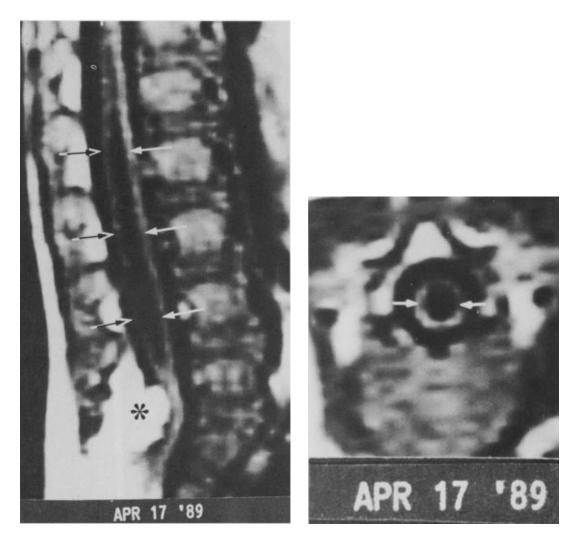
shows another MRI scan, taken when the baby was 1 year and 3 months old. Just like in the previous scan, it's a T1-weighted MRI. The image on the left is a side view (sagittal), and the one on the right is a front view (coronal). In this scan, you can see that the fatty lump inside the spine (marked by an asterisk) has grown a lot, and there's now a big pocket of fluid called syringomyelia (shown by arrows).
